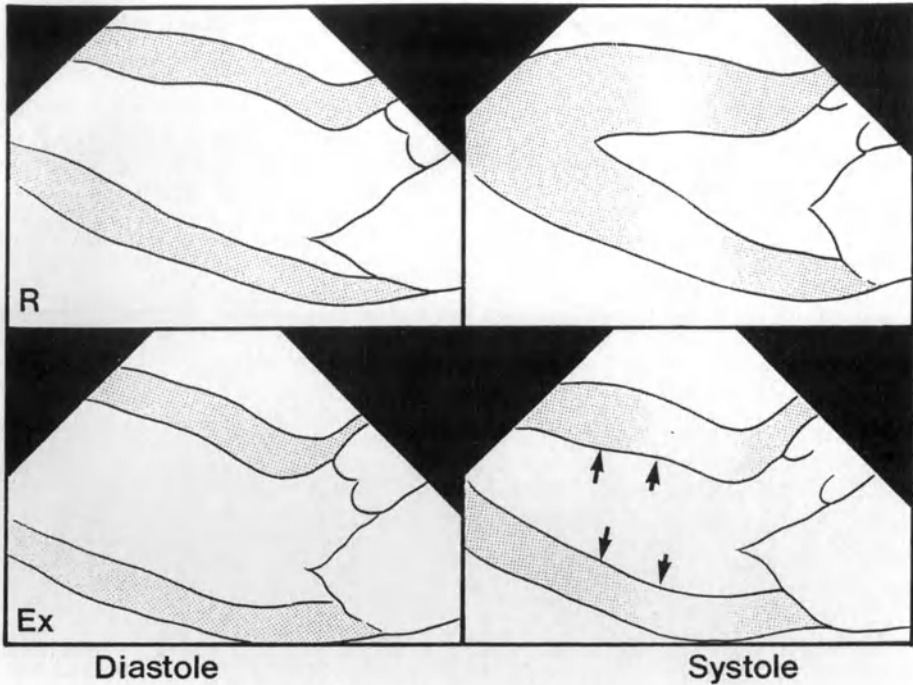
Freeze-frame images and traced outlines of the parasternal long axis view of the left ventricle. There is normal resting function (R), with reduction of anteroseptal and posterior
